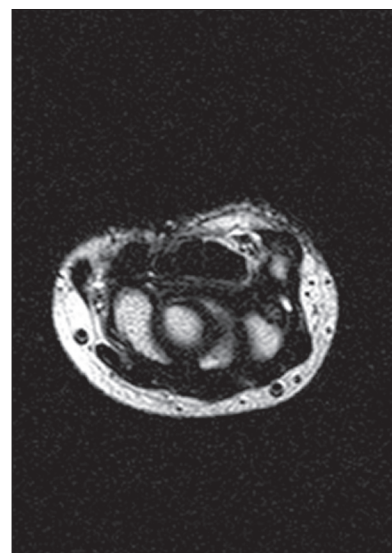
Transversal plane T2-weighted magnetic resonance imaging; the pisometacarpal ligament is elongated and heterointense, with partial interstitial rupture
